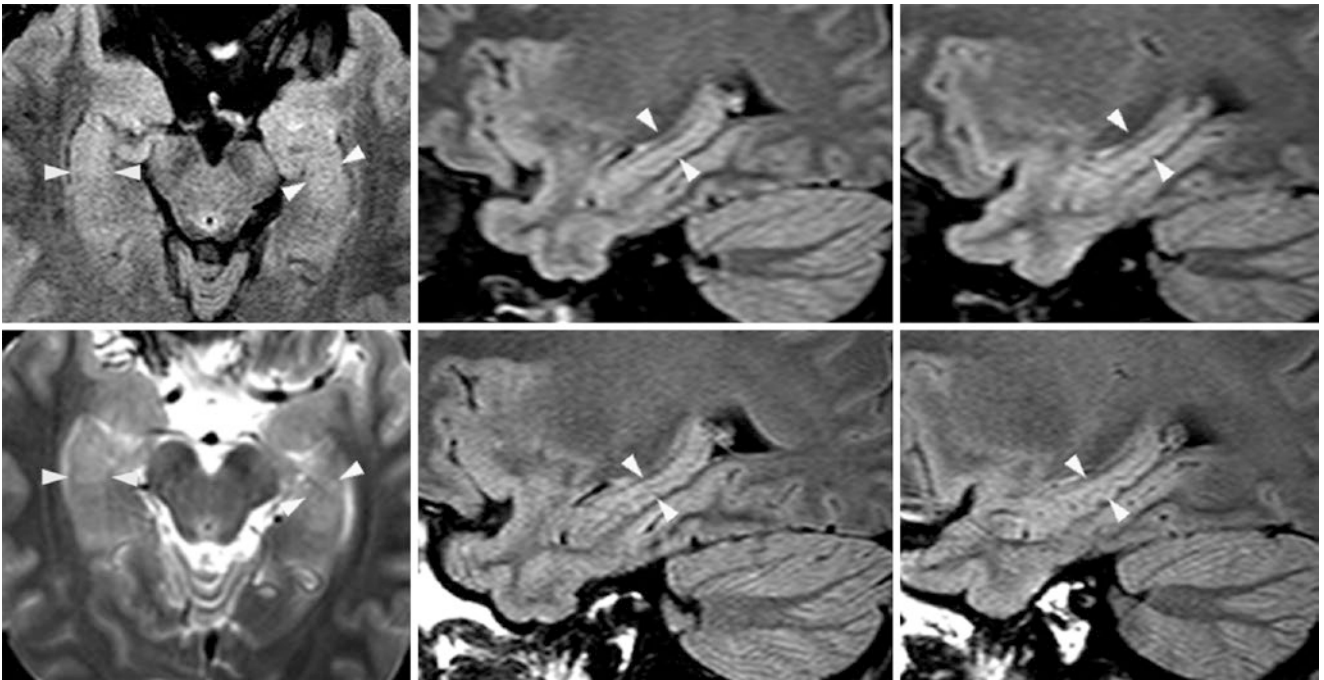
A 28-year-old had a 3 T MR with axial (*top left*) and sagittal FLAIR images of the right (*top middle*) and left (*top right*) sides, which depict bilaterally hyperintense hippocampi, amygdala, and superior temporal gyri (*all between arrowheads*). These temporal lobe areas
